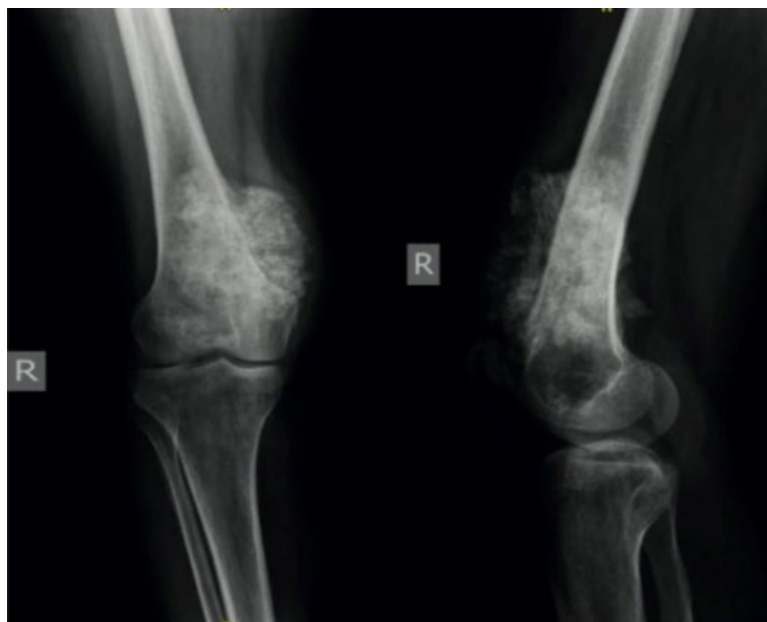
Radiographs. Osteosarcoma of the distal metaphyseal part of the right femur
